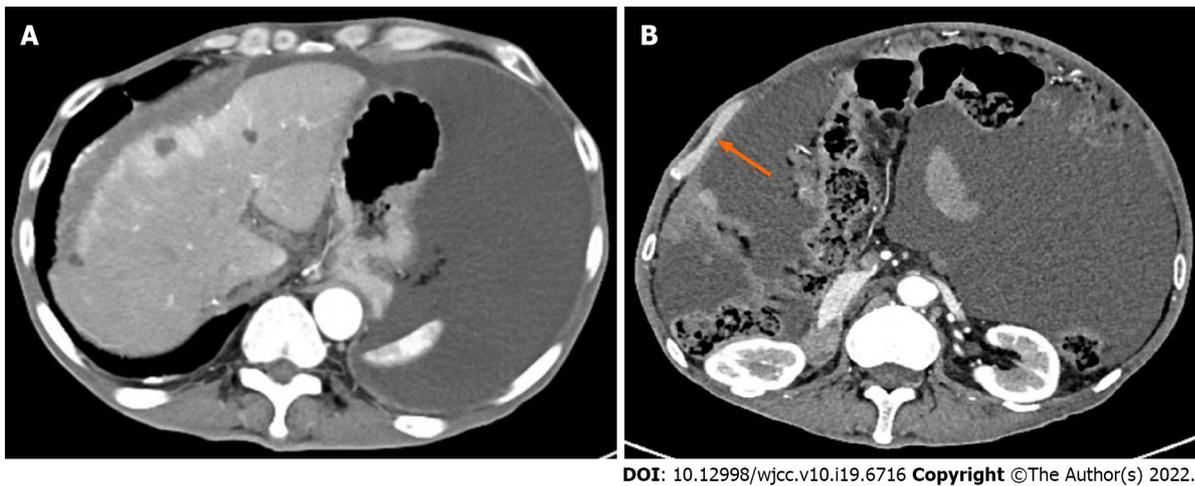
Computed tomography images. A: Abdominal computed tomography revealed multiple hepatic cysts, liver cirrhosis and ascites; B: The right peritoneum was irregularly thickened.
